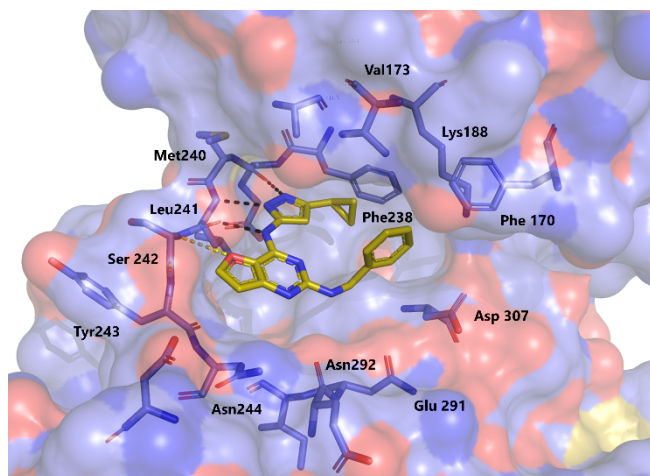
X-ray structure of compound 131 in complex with DYRK1A.
